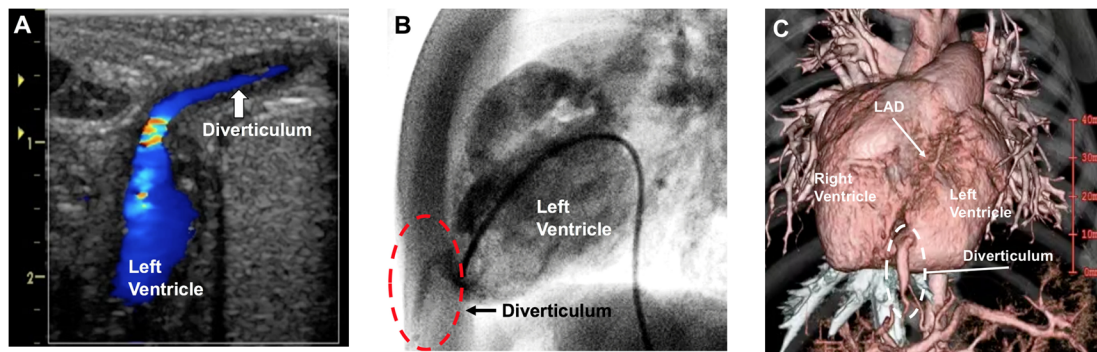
(A) Echocardiography demonstrated blood flow in and out of the pulsatile mass. The white arrow indicates the diverticulum. (B) Angiography of left ventricle shows the diverticulum (red dotted circle) as an outpouching of the left ventricular apex. (C) Computed tomographic angiography shows the diverticulum (white dotted circle) as an elongated contrasted-filled outpouching arising from the left ventricular apex. The neck of the diverticulum is near the left anterior descending coronary artery (white arrow). LAD, left anterior descending.
